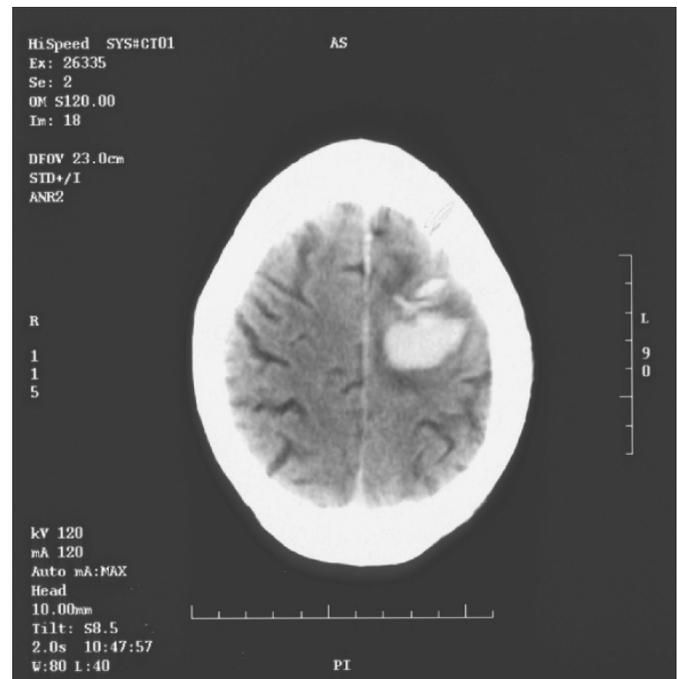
CT brain scan demonstrating an area of high attenuation in the left parietal region, consistent with a recent intracerebral hemorrhage
